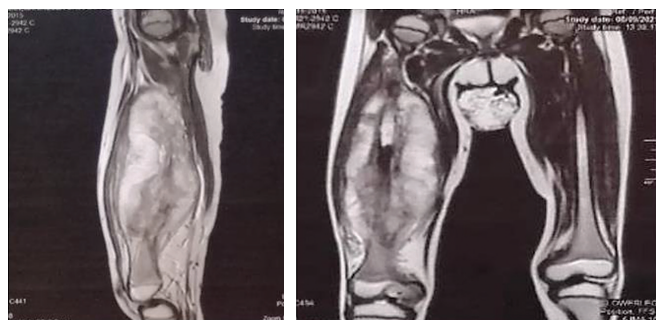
Pre-operative MRI of the patient's right thigh showing a femoral midshaft tumor.
